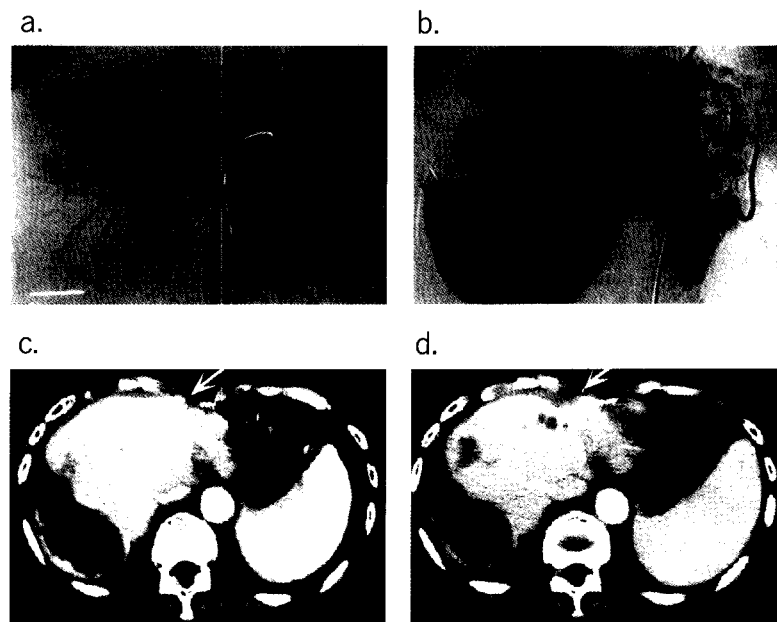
Changes in angiography images and contrast-enhanced computed tomography (CE-CT) after percutaneous microwave coagulation therapy (PMCT).
